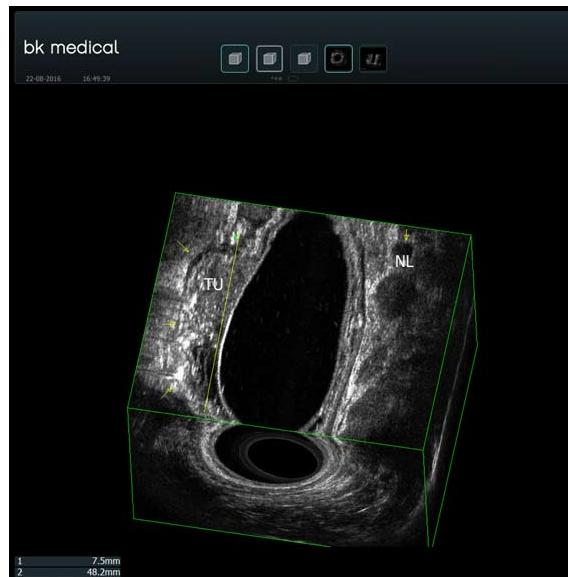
Rectal adenocarcinoma staging by 3D endoscopic ultrasound T1 N1. The yellow arrows on the left show the muscularis propria. The tumor invades up to the submucosa. A white submucosa plane can be seen between the tumor (TU) and the muscularis propria. The yellow arrow on the right shows a round lymph node. The 3D image was obtained using a transanal rigid probe with an ultrasound from bk medical.
